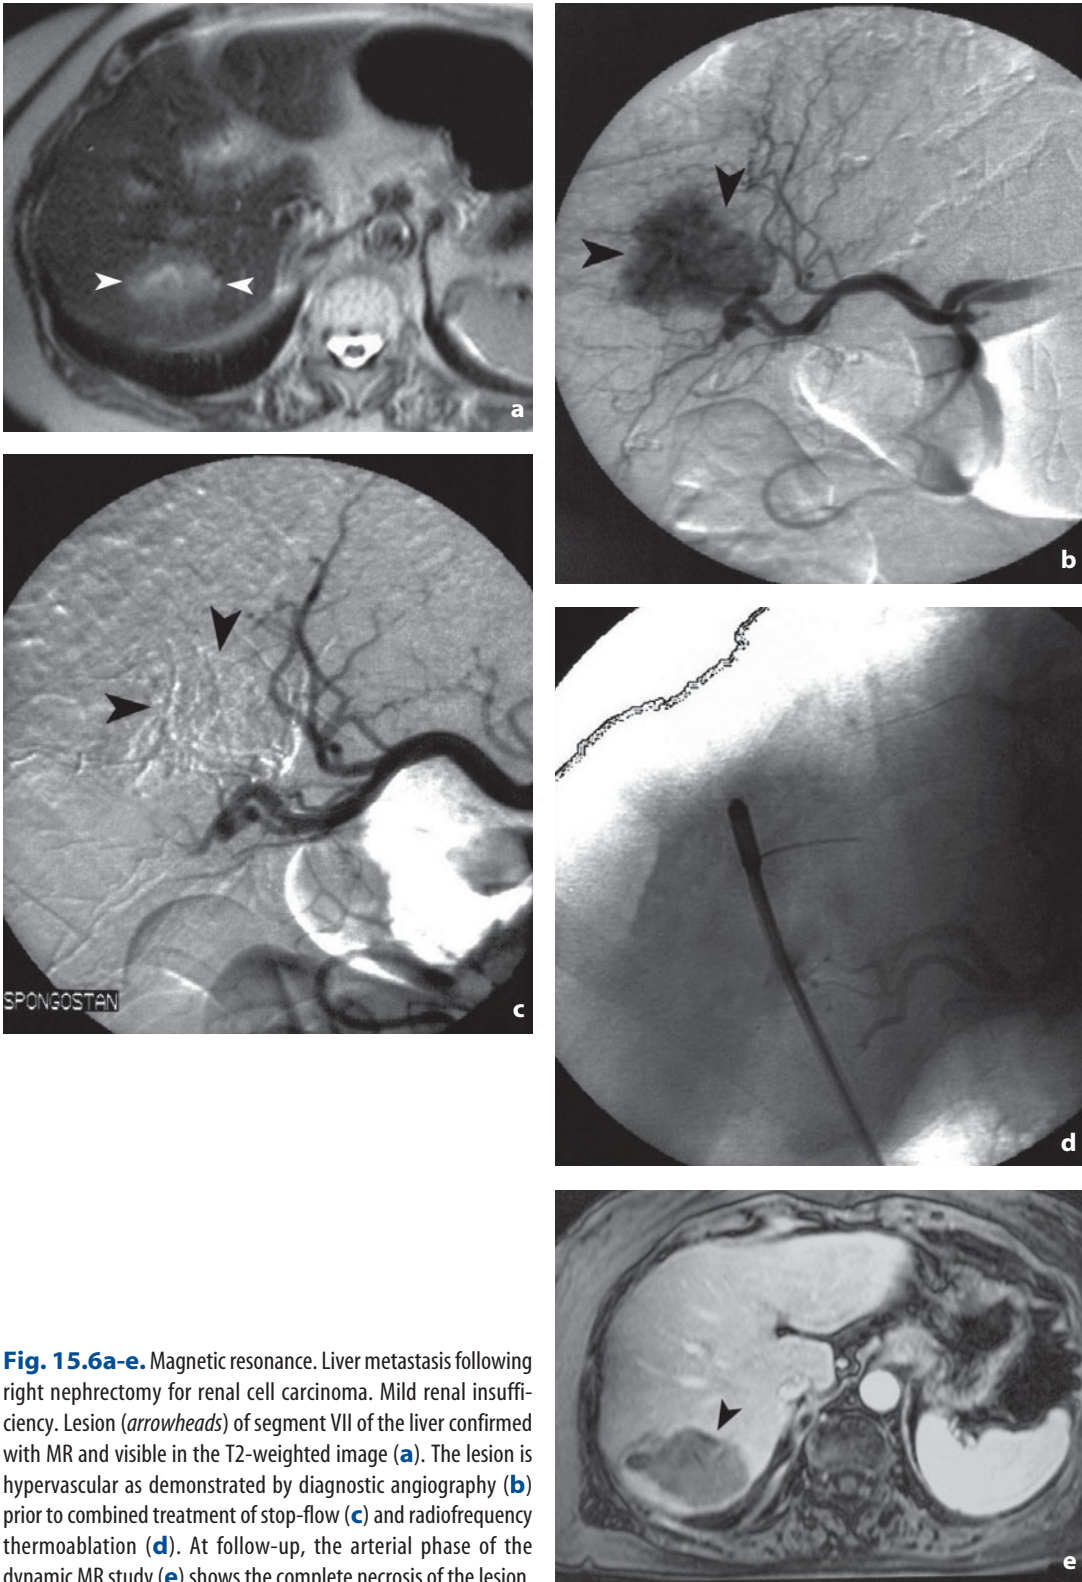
Magnetic resonance. Liver metastasis following right nephrectomy for renal cell carcinoma. Mild renal insufficiency. Lesion (*arrowheads*) of segment VII of the liver confirmed with MR and visible in the T2-weighted image (a). The lesion is hypervascular as demonstrated by diagnostic angiography (b) prior to combined treatment of stop-flow (c) and radiofrequency thermoablation (d). At follow-up, the arterial phase of the dynamic MR study (e) shows the complete necrosis of the lesion
